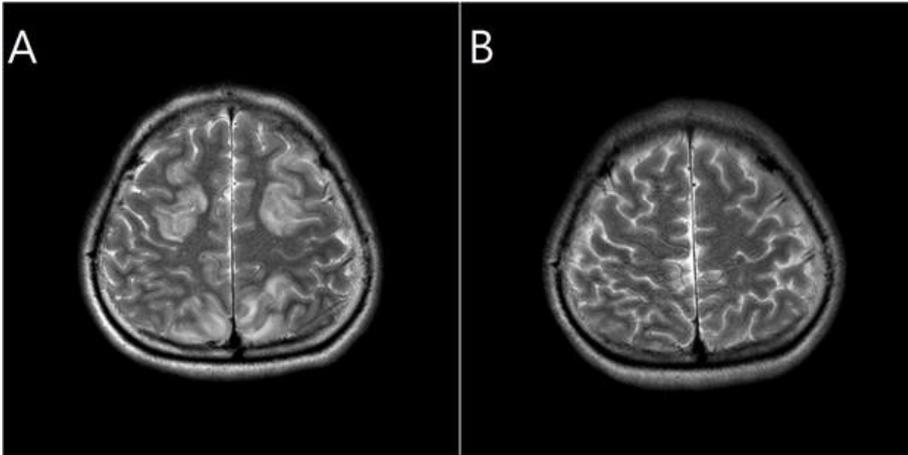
Brain magnetic resonance imaging performed on the POD 10(A), POD 21(B). Axial T2-weighted images of POD 10(A) revealed both frontal and parietal cortex and subcortical white matter signal intensity change. POD 21 images(B) revealed complete remission.
